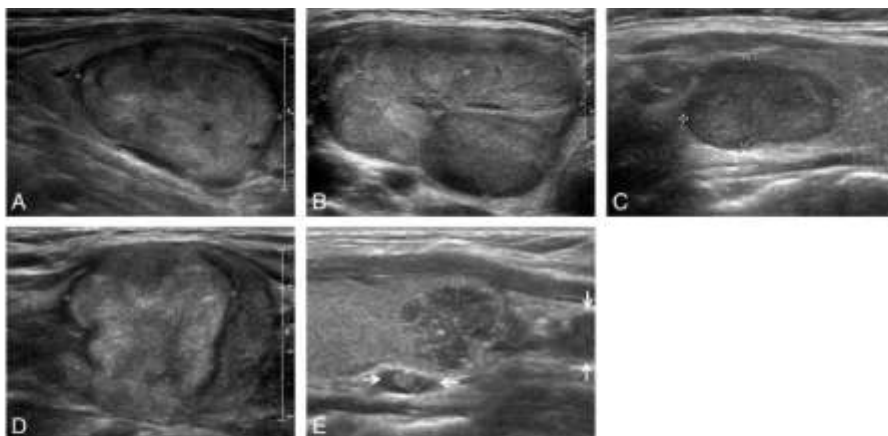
Sonographic patterns of various degrees of benignity and malignancy in solid thyroid nodules
